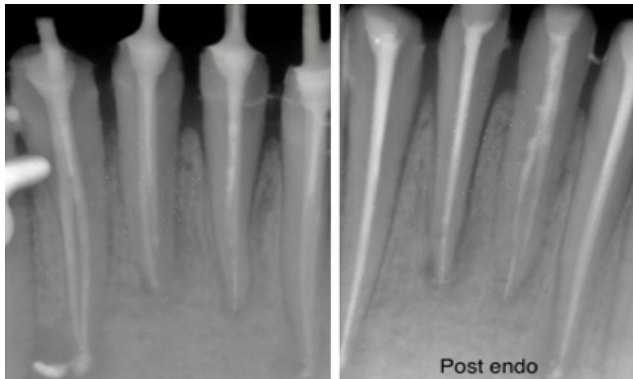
Master cone and post obturation radiographs
